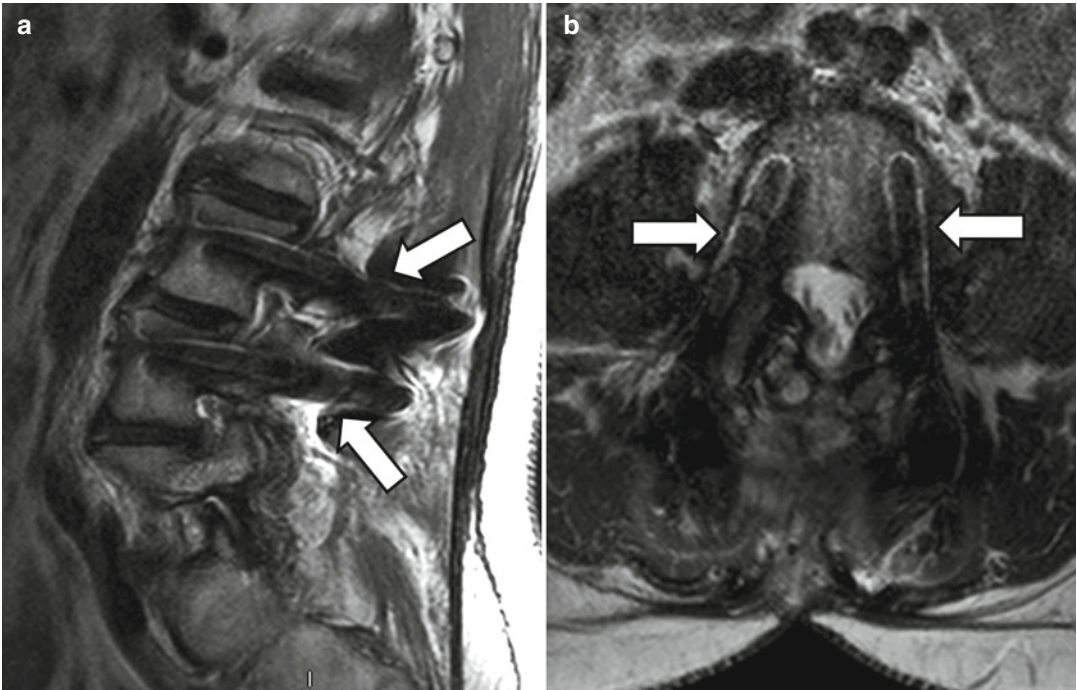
Sagittal (a) and axial (b) T2-weighted sequences at the level of posterior spinal instrumentation demonstrate susceptibility artifact typical of present-day titanium spinal hardware (arrows). Titanium implants are
